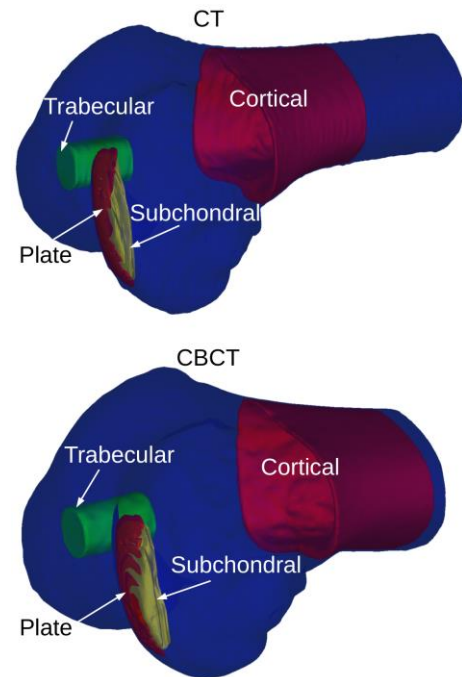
Three-dimensional masks for vBMD analysis of cortical bone (Cortical), trabecular bone (Trabecular), subchondral trabecular bone (Subchondral) and subchondral plate (Plate) in a knee imaged with CT and CBCT scanners.
